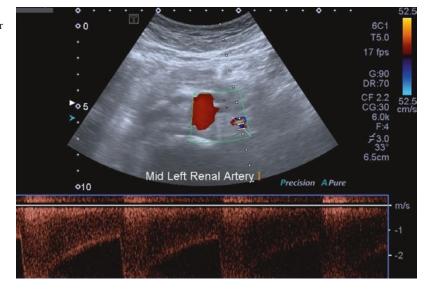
Fibromuscular dysplasia. Transverse color Doppler view showing at the mid tract of left renal artery a focal zone of aliasing and a pulsed Doppler waveform with elevated PSV (>300 cm/s)
